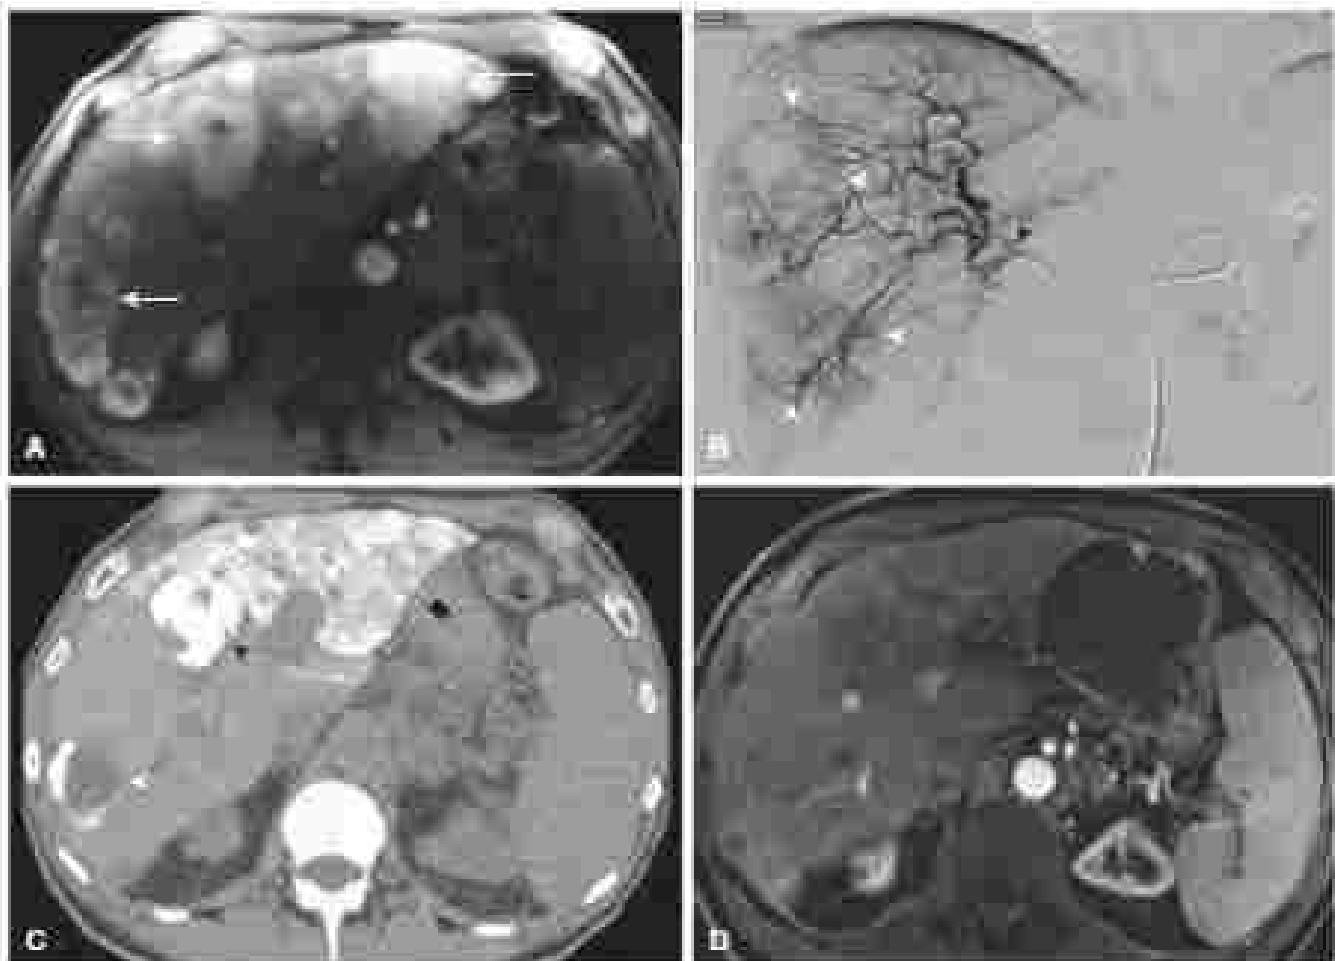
A 70-year-old man with primary pancreatic neuroendocrine tumor. (A) Axial contrast-enhanced T1-weighted magnetic imaging shows a hypoenhancing neuroendocrine metastasis in the liver (arrow). (B) T1-weighted MR angiogram of the right hepatic artery during transarterial chemoembolization (TACE) shows the hypervascular mass (arrowhead). The patient underwent a course of 4 TACEs over 4 months. (C) Axial contrast-enhanced computed tomography at post-TACE day 40 after last TACE shows a filling defect in the hypervascular mass (arrowhead) and a stranding (arrow) proximal to the right hepatic lobe (arrow). (D) Axial contrast-enhanced T1-weighted magnetic imaging 2 years after treatment shows non-enhancing and persistent regions with minimal radiologic evidence of disease.
